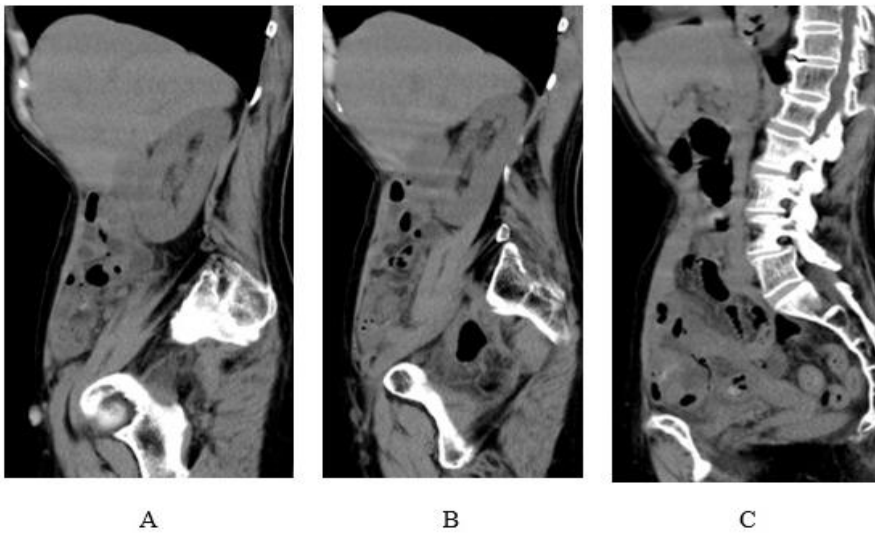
A tubule with mural thickness is difficult to differentiate swollen appendix from external iliac artery on sagittal CT (A-C).
